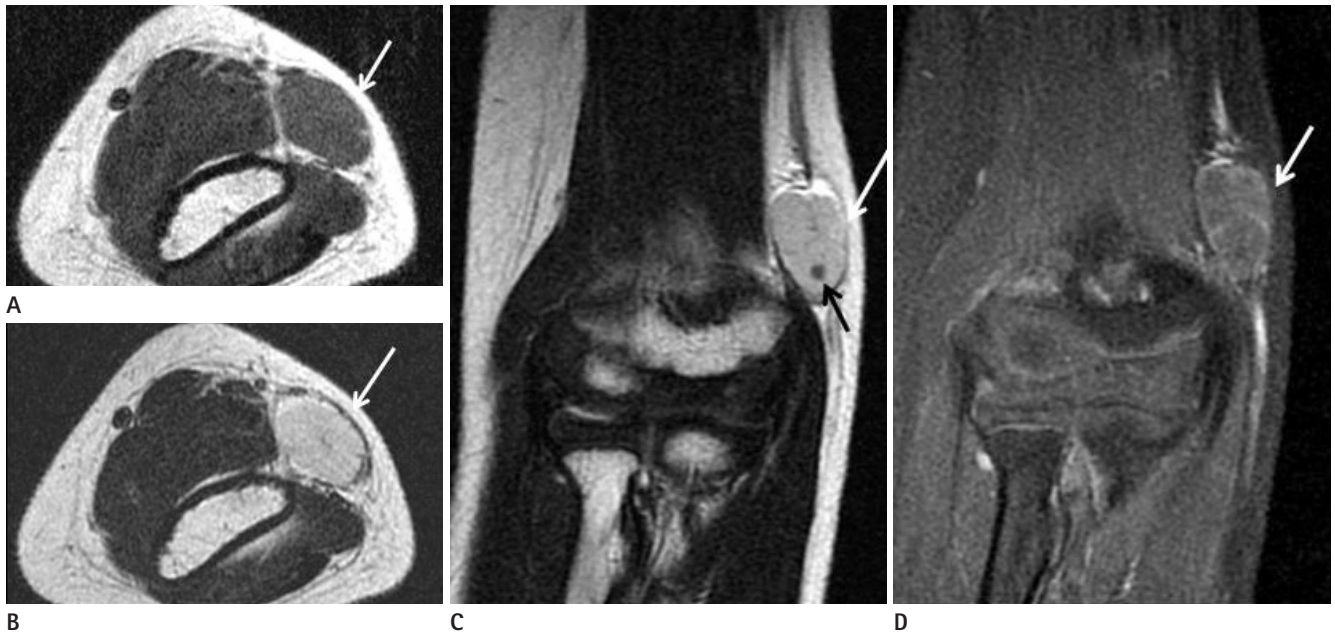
MR imaging findings for the case study. Axial (A) T1-weighted SE image (TR: 450, TE: 11) shows an isointense mass (arrow). Axial (B) and coronal (C) T2-weighted SE image (TR: 2967, TE: 88 ms) shows homogeneous high signal intensity of the entire mass (white arrow) with thin hypointense septae and a focal dark signal intensity (black arrow). A coronal (D) contrast-enhanced T1-weighted image shows peripheral and septal enhancement of the tumor (arrow).
